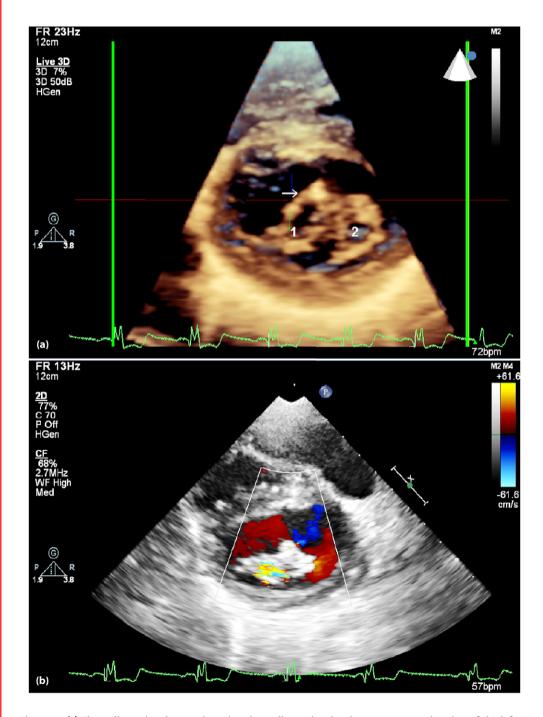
(a) Three-dimensional trans-thoracic echocardiography showing a post-operative view of the left AV valve. Arrow: the site of cleft closed. 1: the larger anterolateral orifice. 2: the smaller posteromedial orifice. (b) Short axis view for the left AV valve with color Doppler showing mild regurgitation from the smaller orifice.
